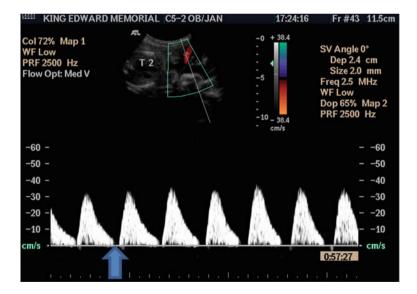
Abnormal UA Doppler: absent flow in the umbilical artery Doppler. Arrow—absence of diastolic flow. Published with permission, courtesy of Dr. EF Magann
